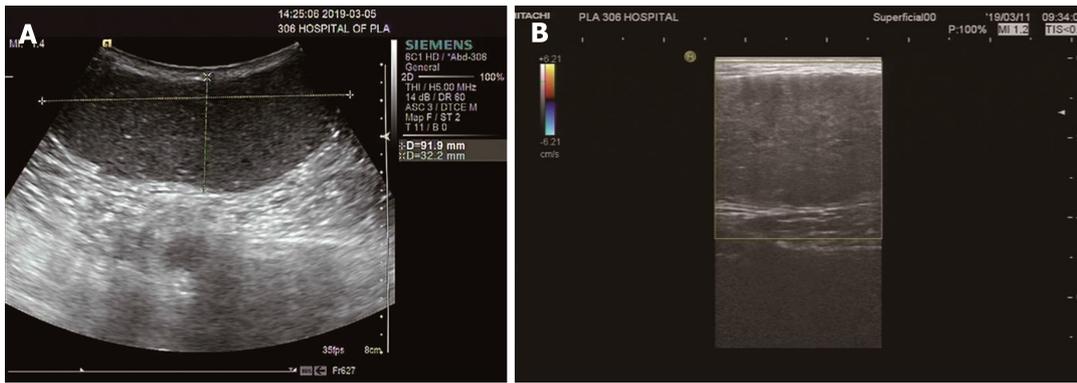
Ultrasound images. A: Ultrasound image showing a hypoechoic mass, with the maximum range of 9.2 cm × 3.7 cm, clear margins, and regular morphology; B: Color Doppler flow image indicating that there was no obvious blood flow in the mass.
